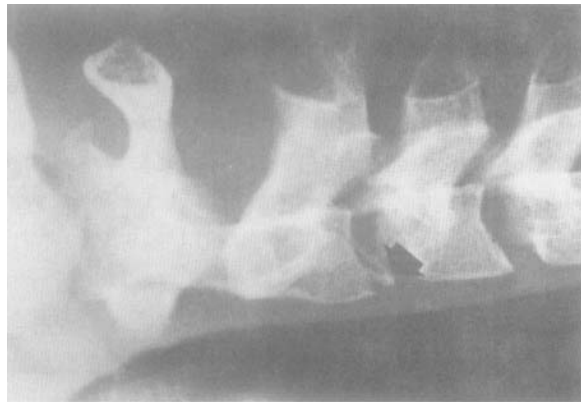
Case 16. Lateral radiograph of upper cervical spine to demonstrate avulsion of the ring apophysis of the inferior aspect of the second cervical vertebra due to rapid distraction.
